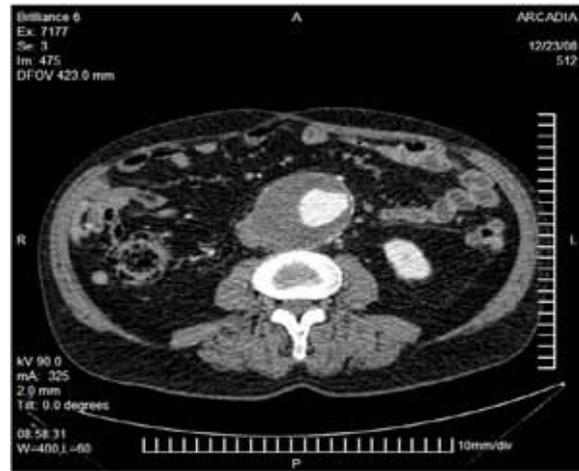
Axial CT of the abdomen with contrast shows infrarenal AAA with a large circumferential thrombus.
